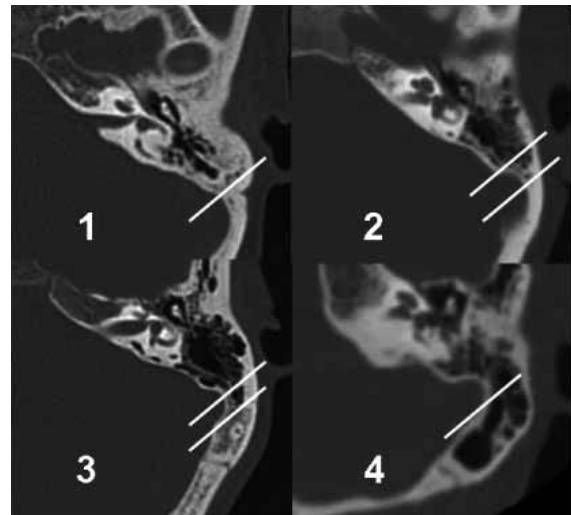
Axial CT scans demonstrating temporal bone pneumatization classification. At the level where the malleoincudal complex appeared as an ice-cream cone shape, three parallel lines were drawn crossing the sigmoid sinus at the most anterior portion of the sigmoid sinus, the most lateral aspect of the sinus, and the most posterior point of the sinus were drawn at 45° in the anterolateral direction. TBP was classified as a (1) if air cells were not present or present only anterior to the anterior line, a (2) if air cells extended beyond the anterior line but not beyond the line through the lateral aspect of the sigmoid sinus, a (3) if the air cells extended beyond the line through the most lateral aspect of the sigmoid sinus but not the most posterior line, and a (4) if the air cells extended beyond the most posterior line.
